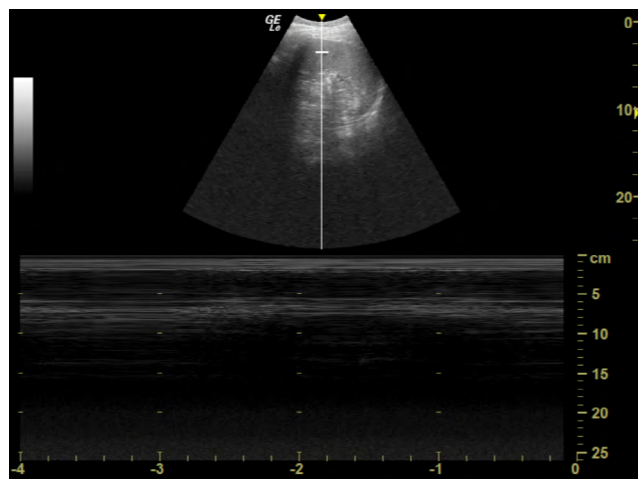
M-mode diaphragm ultrasound image.
